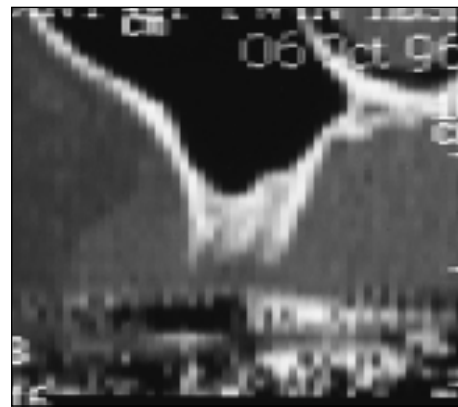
CT scan showing lack of necessary alveolar bone height for implant placement.
